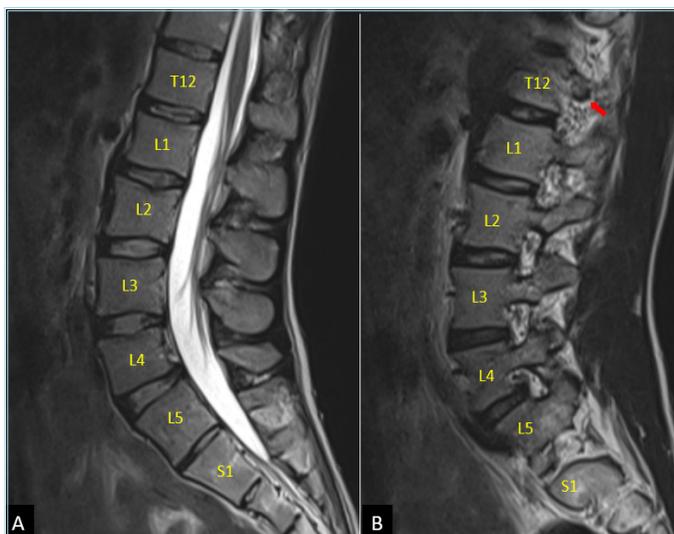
Sacralization of L5. Sagittal plane T2W lumbar magnetic resonance images (MRI) (A, B) showing the sacralized 5th lumbar vertebra. The 12th thoracic vertebra was confirmed by observing the 12th rib (red arrow) on sagittal T2W MRIs
